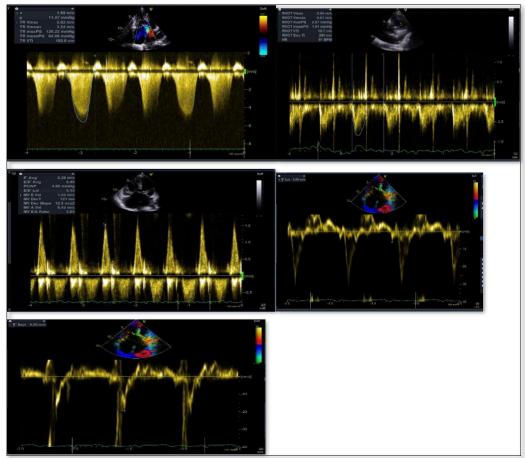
Transthoracic echocardiography High probability of PH with PVR 3.165 Wood Unit, E/e' 11.76.
